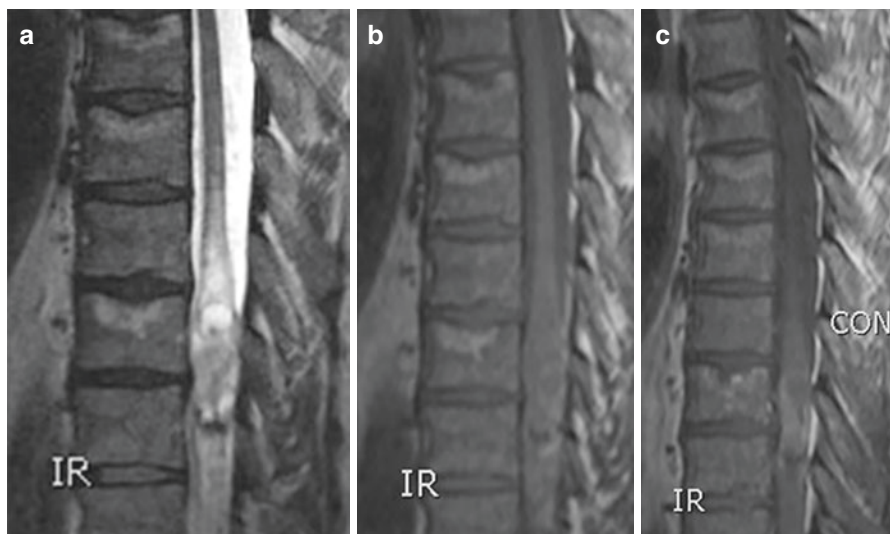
Cellular ependymoma MRIs. Sagittal T2-weighted (a), sagittal T1-weighted (b), sagittal contrast enhanced T1-weighted (c) MRIs showing intramedullary mass in the thoracic spinal cord with hemosiderin deposits on caudal margin “cap sign” and cyst formation on the cranial part of tumor. Enhances after contrast administration
